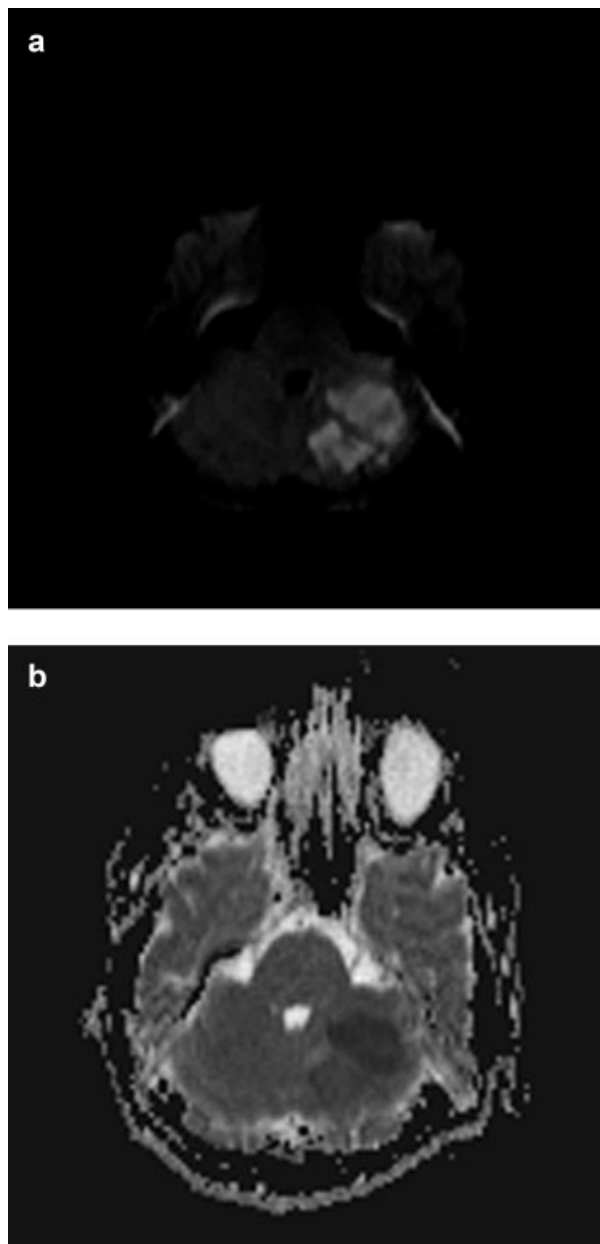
Brain MRI. (a) Diffusion-weighted MR image ($b = 1,000$ s/mm²) shows the area of increased signal intensity in the left cerebellar hemisphere. (b) ADC map shows decreased ADC values in the same area. These findings are indicative of acute ischemia.
